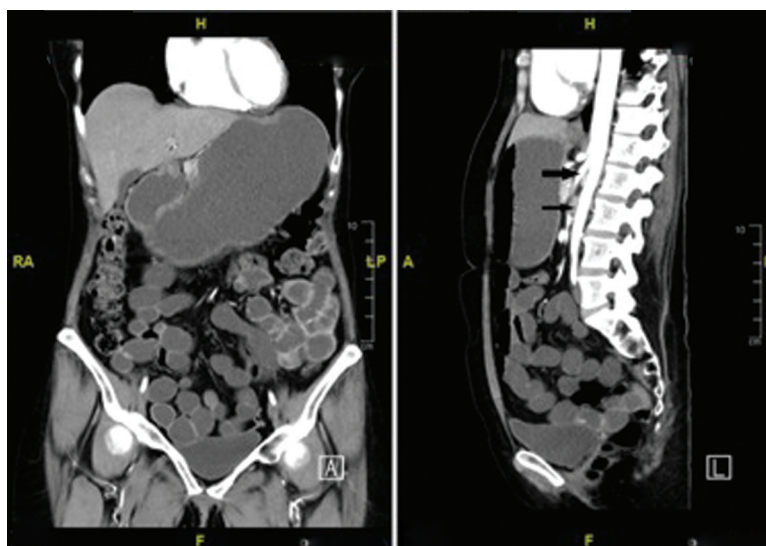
Contrast-enhanced computed tomography scan showing a distended stomach (left) with the angiogram (right) showing compression of the duodenum (lower arrow) between the superior mesenteric artery (upper arrow) and the aorta.
